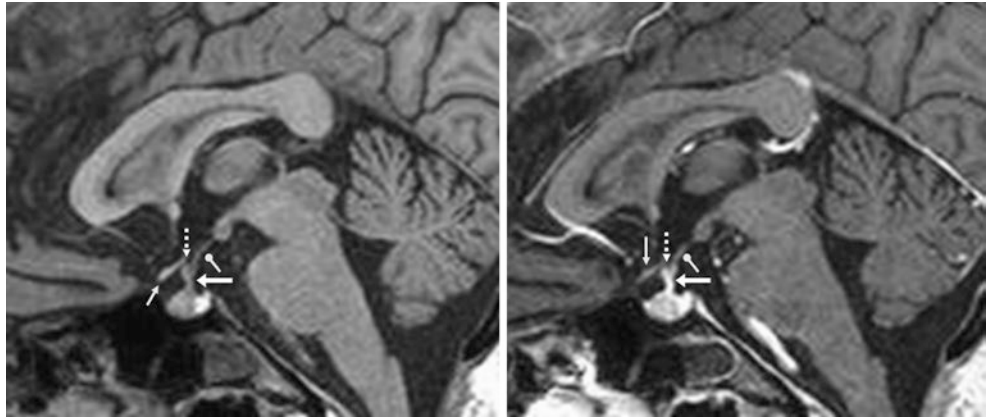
A 35-year-old female patient; 1.5 T MRI sagittal pre- (*left*) and postcontrast (*right*) FLAIR images depict normal enhancement of the infundibulum (*arrows*), tuber cinereum (*circle tip arrows*), and median eminence (*dashed arrows*) relative to the nonenhancing optic chiasm (*thin arrows*). A faintly enhancing lamina terminalis (*arrowheads*) can be noted on the postcontrast image, since that structure also does not have a blood–brain barrier
